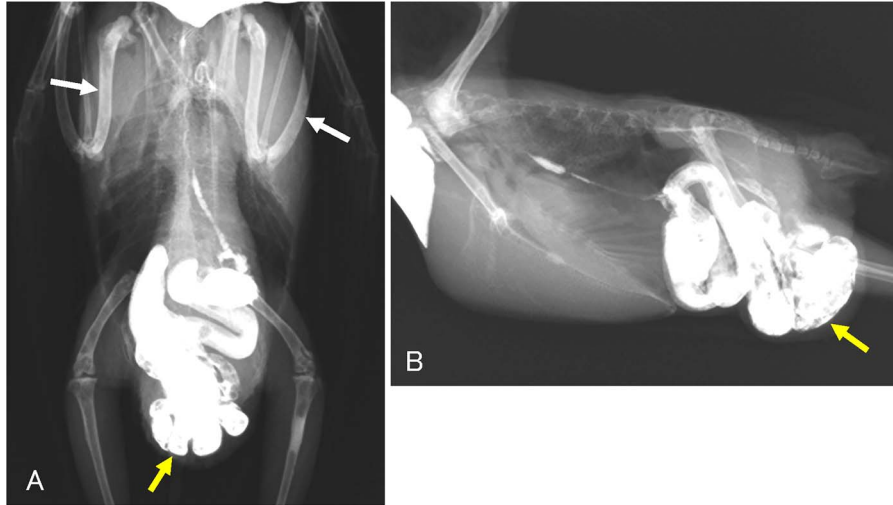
(A) Ventrodorsal and (B) right lateral contrast barium gastrointestinal radiographs of the 3-year-old female budgerigar (*Melopsittacus undulatus*) from case 2. Hyperostotic polyostosis, primarily in the humeri and ulnae (white arrows), was seen, and approximately half of the intestines herniated through the body wall (yellow arrows).
